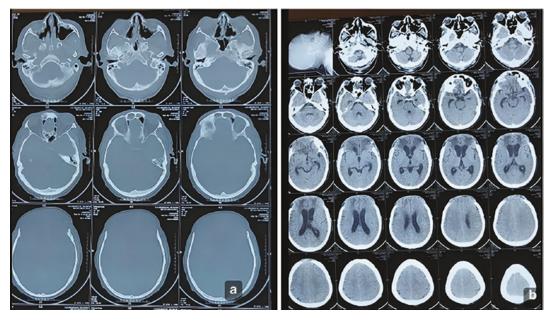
Ninth postoperative month CT scan. Debrided frontal bone is shown in axial bony window cuts in panel (a). Panel (b) indicates locoregional disease management
